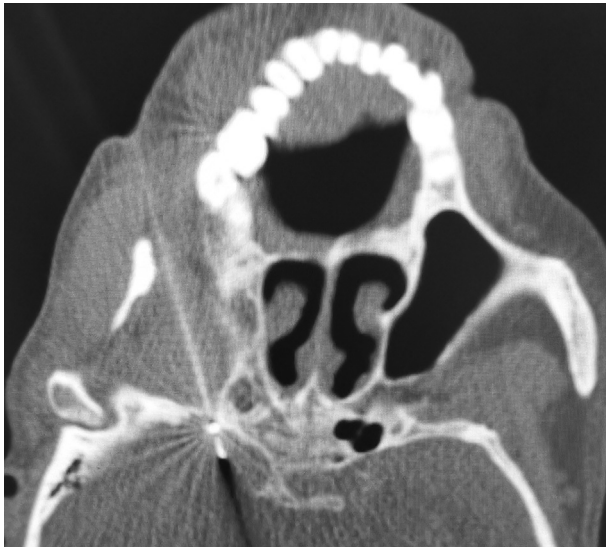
Representative computed tomography (CT) image of pulsed radiofrequency (PRF) needle puncturing arrived at gasserian ganglion.
